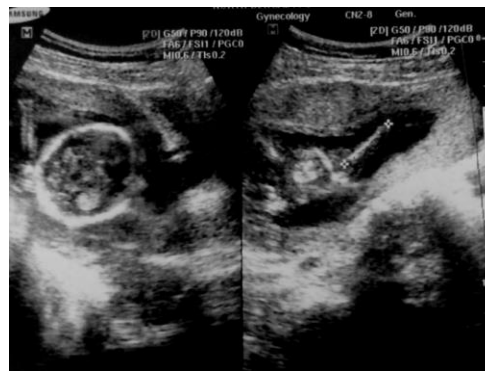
Repeat ultrasonogram of 18 weeks live pregnancy
